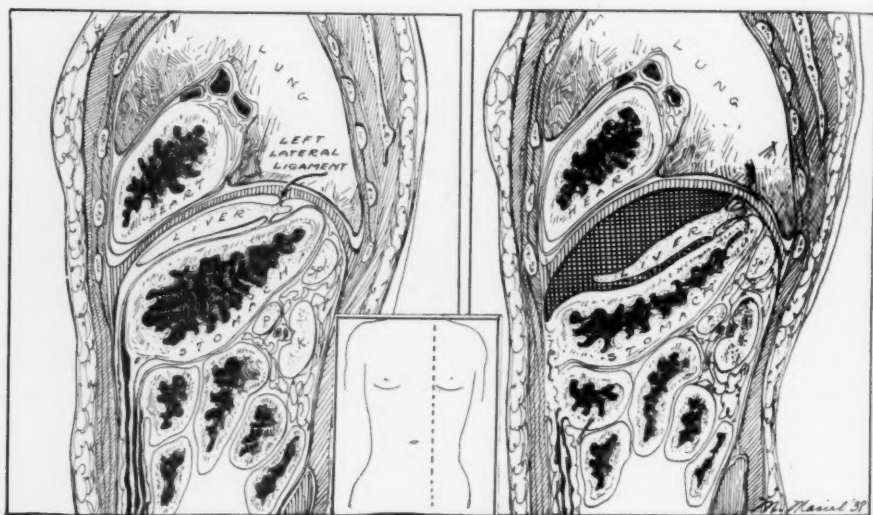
The anatomy of a left anterior intraperitoneal subphrenic abscess in the parasternal line. A normal section is shown on the left. Note that the left lateral ligament of the liver forms the posterior boundary of the abscess at this level. The stomach, by adhering to the anterior abdominal wall, has limited the abscess below so that the abscess barely presents below the costal margin.
